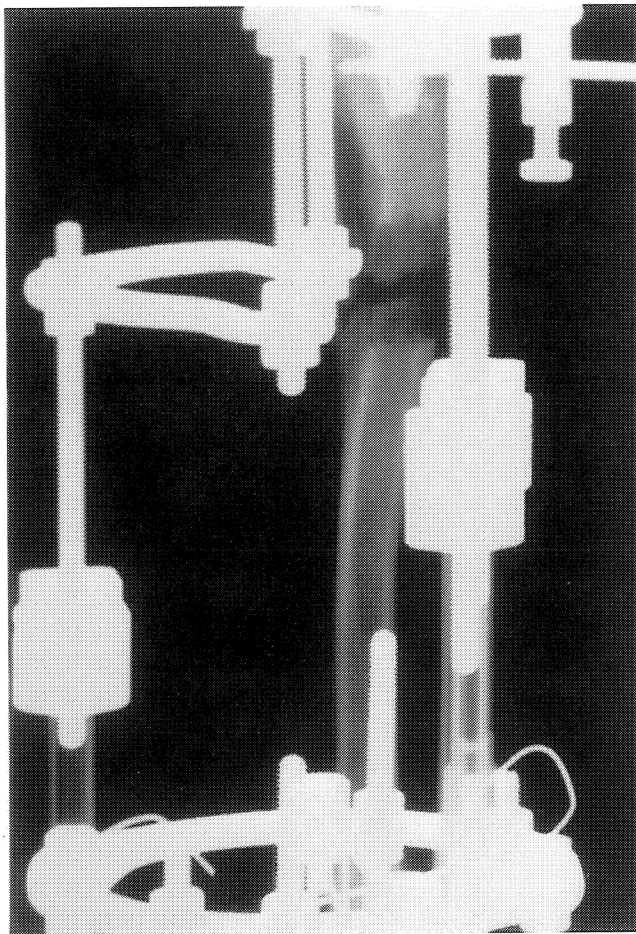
Lateral roentgenogram at one week post-distraction. Parallel columns of bone emanate from both corticotomy surfaces towards a central radiolucent plane.
